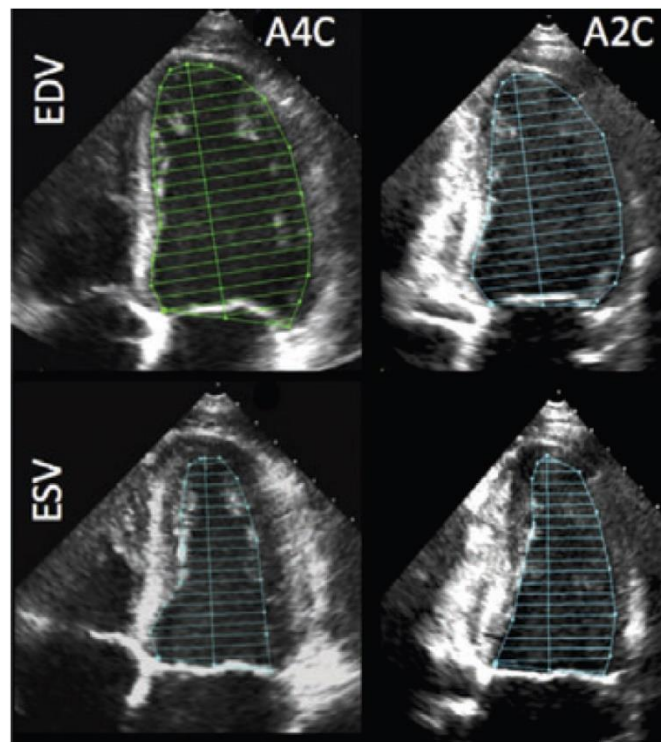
Example of echocardiographic assessment of the LV in the left-lateral decubitus position.
